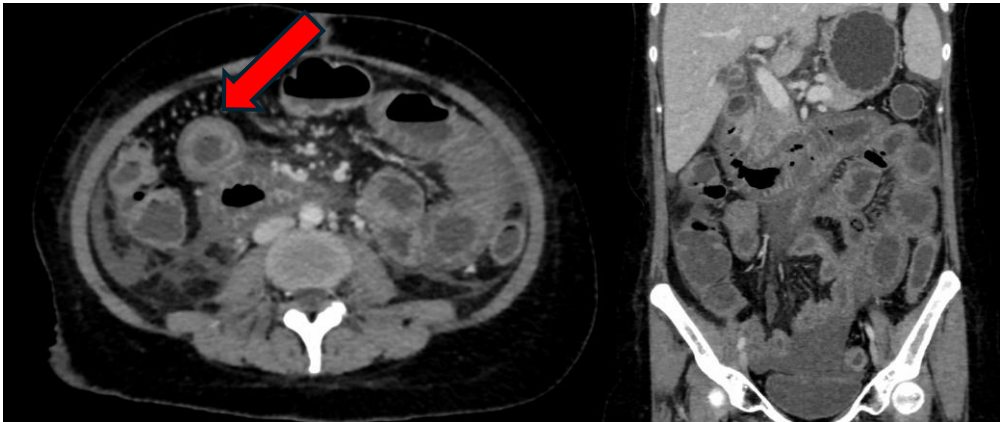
Abdominal CT scan – dilatation of intestinal segments, with circumferential, multisegmented mural thickening of over 3mm, affecting mainly the duodenum until the distal ileum, with associated submucosal oedema (“target sign” – arrow)
